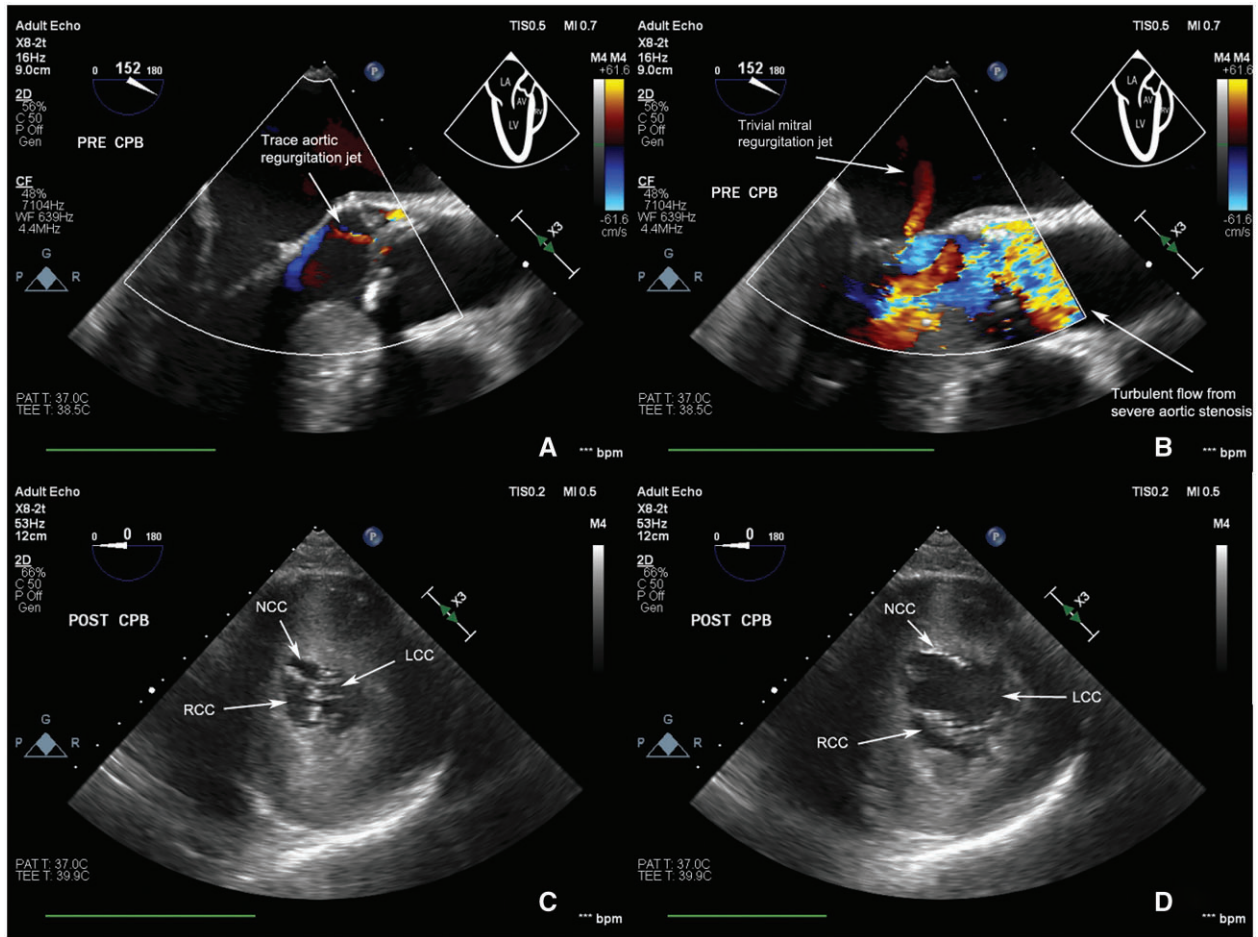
Intraoperative transoesophageal echocardiogram. (A and B) Pre-CPB mid-oesophageal views showing colour Doppler of aortic and mitral valve function. (C and D) Post-CPB mid-oesophageal short-axis view of *Inspiris Resilia* aortic valve in both closed and opened conformations.
